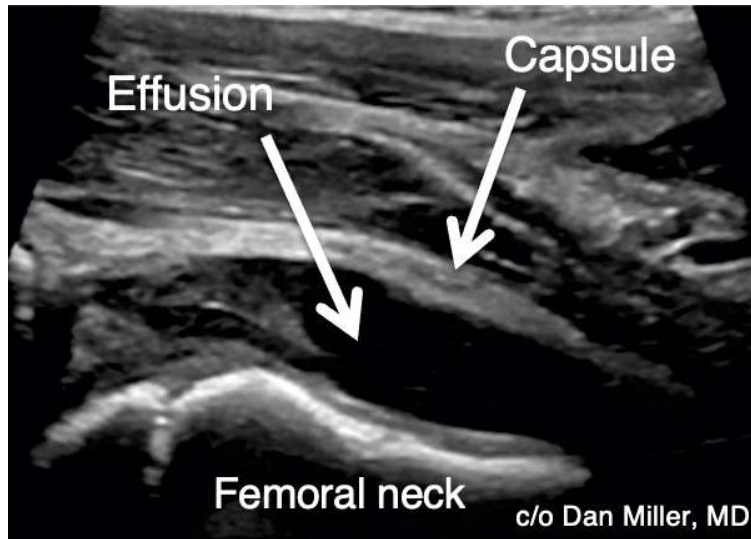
Ultrasound of a patient with a large hip effusion. Note the elevation of the thickened capsule off the anterior femoral neck. (Image courtesy of Dan Miller, MD.)
